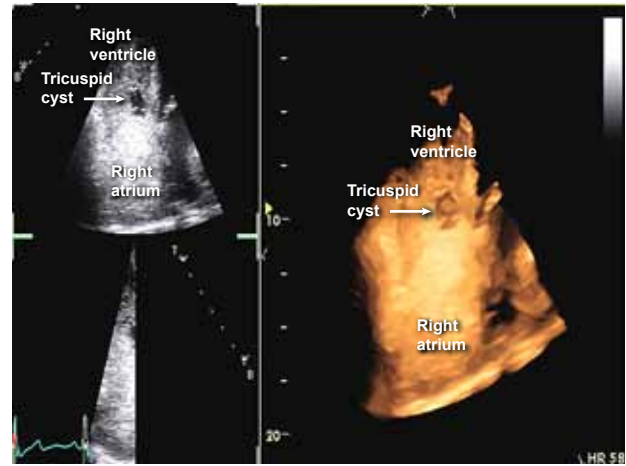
Real-time three-dimensional contrast echocardiography with microbubbles.
